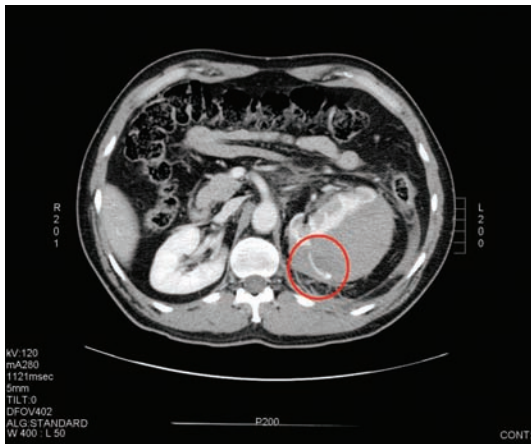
Computed tomography scan with contrast: circle around contrast extravasation indicating active vascular injury.
